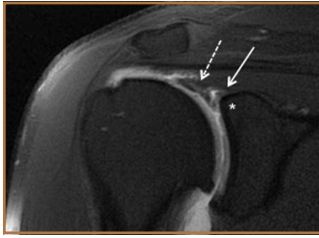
Coronal T1-weighted postarthrographic image shows insinuation of intra-articular contrast at chondrolabral junction of superior labrum (arrow) with extension of contrast into biceps anchor (dashed arrow), consistent with superior labral tear extending into bicipital labral complex. Cartilage fraying and irregularity of superior glenoid articular surface (asterisk) are more conspicuous because of presence of intra-articular contrast.
